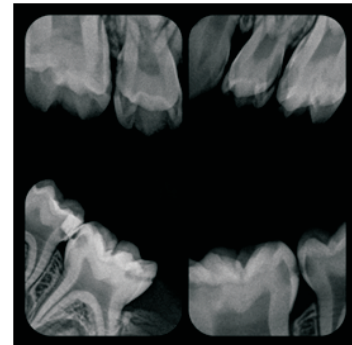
Case 2- Radiographic investigation
